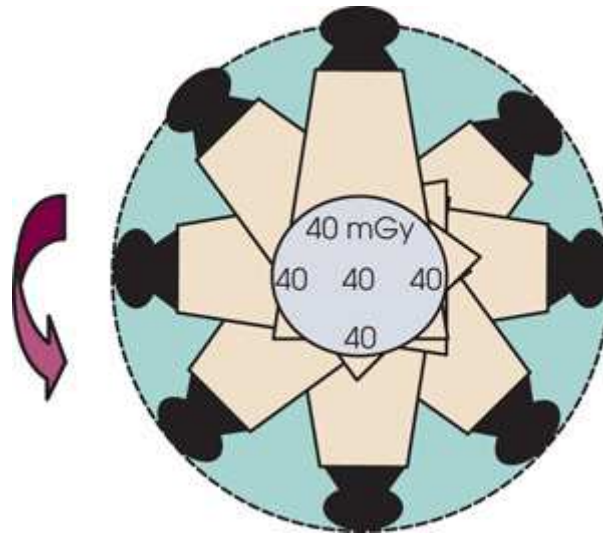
CT dose profile for head. Data from McNitt-Gray MF: AAPM/RSNA physics tutorial for residents: topics in CT. Radiation dose in CT. *RadioGraphics* 22:1541, 2002.
